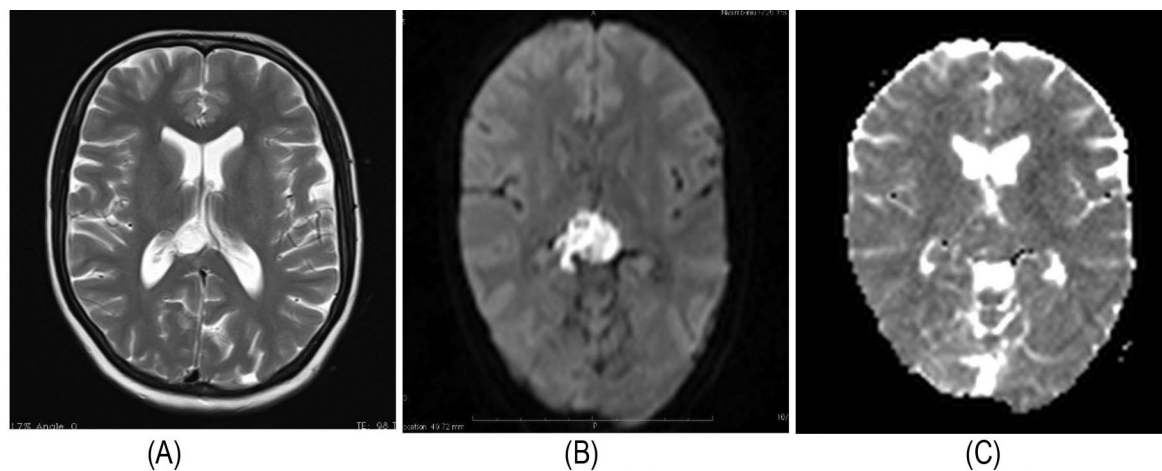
Axial T2W image of epidermoid cyst in right ambient cistern which is isointense to CSF on T2W image (A), showing bright on DWI (B) and dark on ADC (C).
